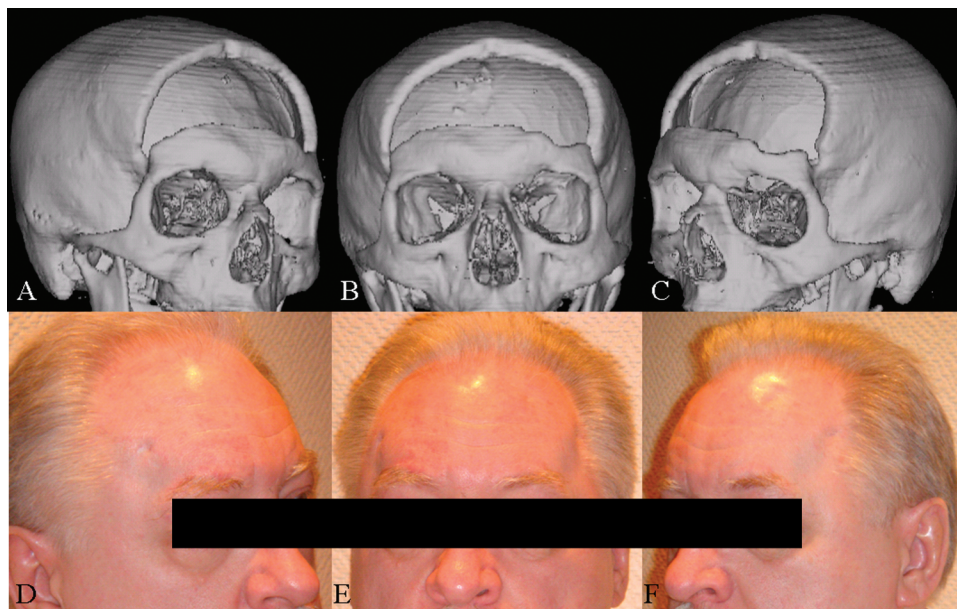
Preoperative CT reconstructions (A–C) and postoperative photographs (D–F) obtained in a 53-year-old patient with the history of a meningioma and subsequent osteolysis of the bifrontal bone flap in left oblique (A and D), frontal (B and E), and right oblique (C and F) views.
